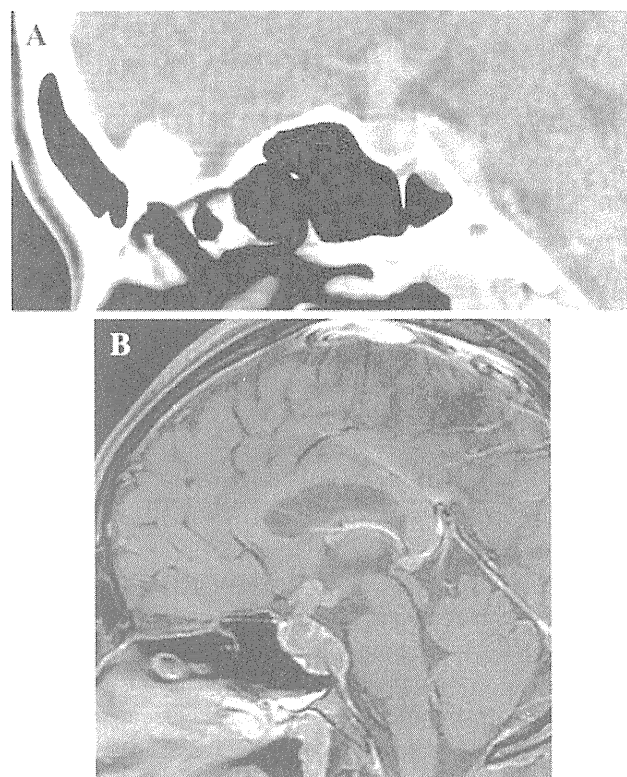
a A sagittal view of computed tomography (CT) image showing an intrasellar mass extending to the suprasellar and the clivus. The mass shows slightly higher density, and no calcification is detected. b Magnetic resonance imaging with gadolinium diethylenetriamine pentaacetic acid (Gd-DTPA) delineates heterogeneously enhanced intrasellar mass and enlarged pituitary stalk
